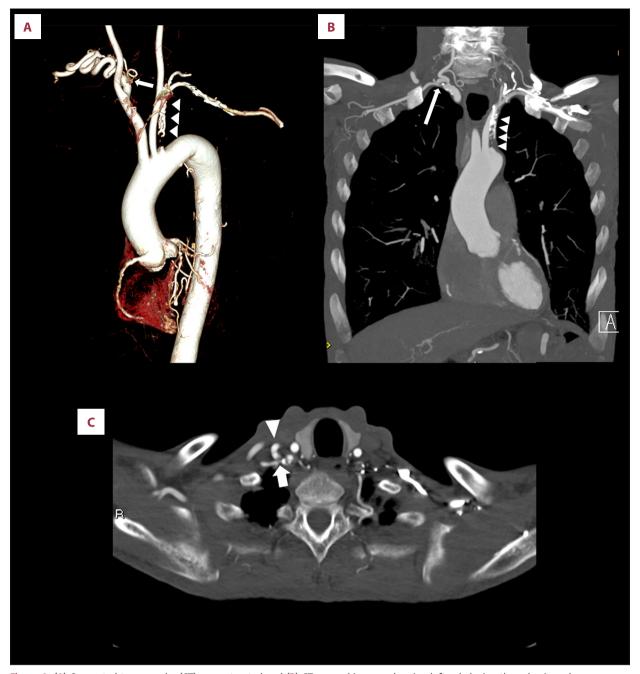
(A) Computed tomography (CT) reconstructed and (B) CT coronal images showing left subclavian thrombosis and atherosclerosis (arrowheads), right subclavian artery stenosis (arrow). (C) CT axial image showing right subclavian thrombosis (arrow) and collaterals from the costocervical trunk (arrowhead).
